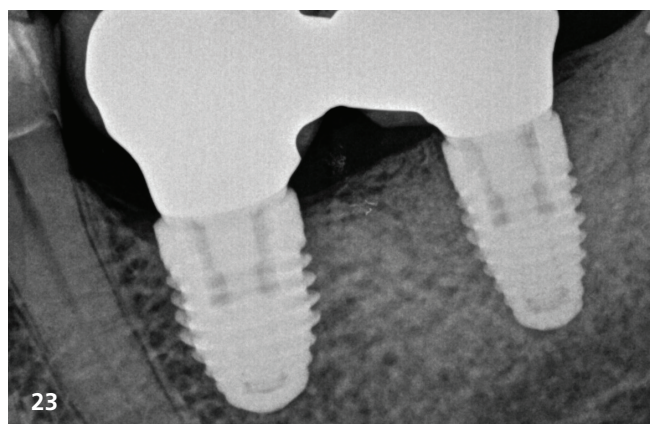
Radiographic assessment at the 2021 follow-up visit, with no complications noted.
